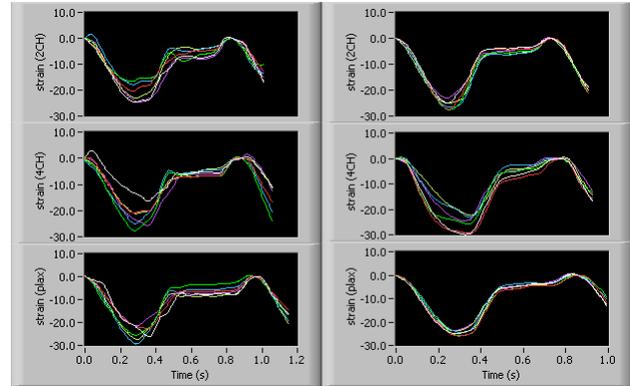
Regional longitudinal strain curves for a normal subject are show in the left column and circumferential curves are shown in the column to the right. Six segments for each echocardiographic view are show; 2-chamber in the top row, 4-chamber in the middle row, and 3-chamber on the bottom row).
